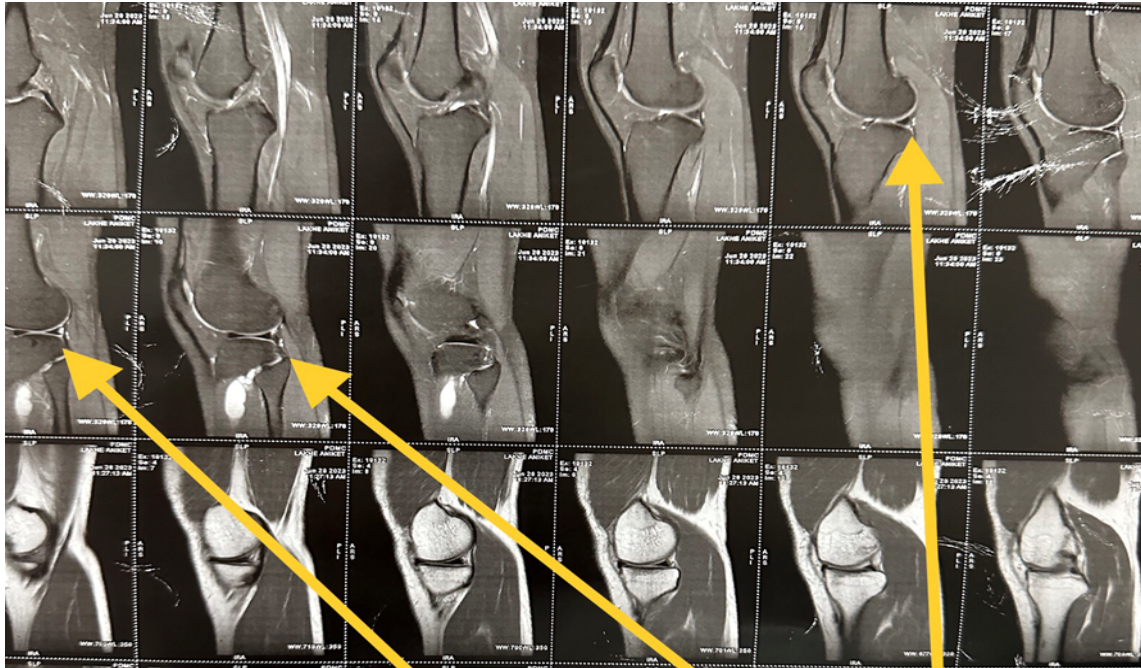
MRI left knee-Sagittal sections
